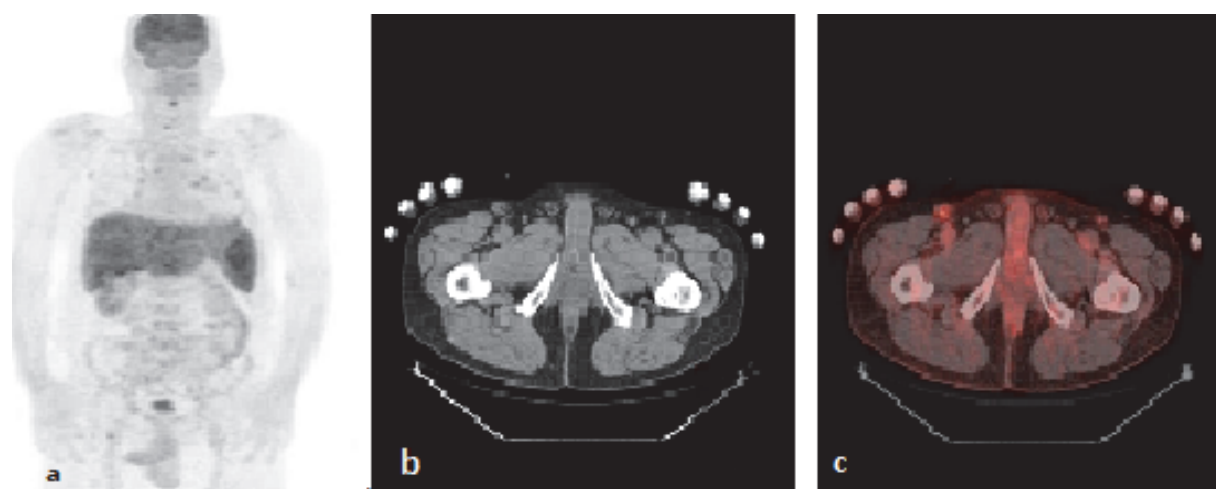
FDG PET of a 64-year-old male patient with diagnosis of sarcoidosis, demonstrates intense diffuse liver and spleen involvement, and vertebral bone involvement more prominent in the cervical area on MIP images (a). Right inguinal lymph node involvement shown on axial CT (b) and PET/CT fusion (c) images of the same patient helped to diagnose as an easy biopsy site.
